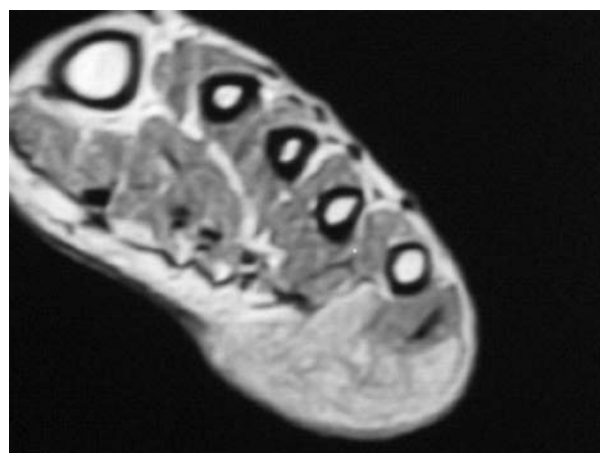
MRI of the left foot shows skin and superficial fascia involvement.
